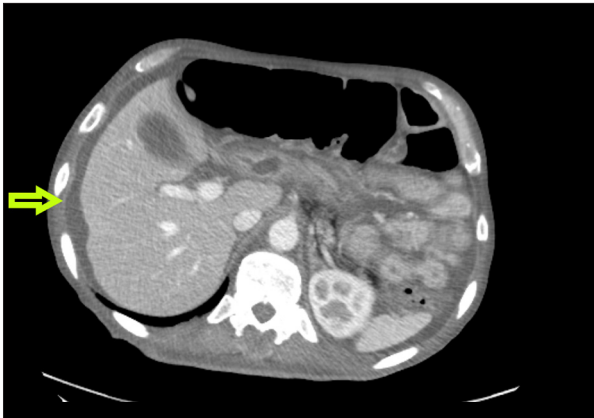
Computed tomography of abdomen and pelvis, showing ascites (yellow arrow).
